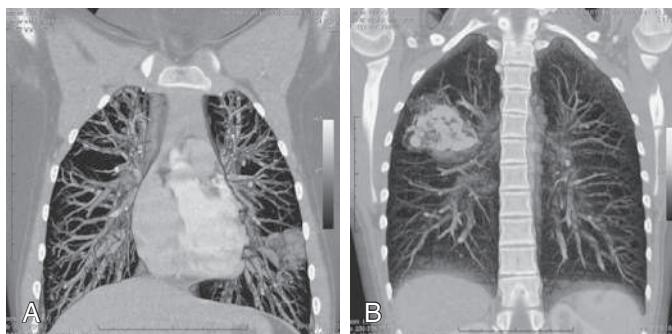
A, Volume-rendering reconstruction of the contrast-enhanced spiral CT showing a large arteriovenous fistula in the left upper lobe (lingula). B, Volume-rendering reconstruction of the contrast-enhanced spiral CT showing an arteriovenous fistula in the right upper lobe. (From Grzela K, Krenke K, Kulus M. Pulmonary arteriovenous malformations: clinical and radiological presentation. *J Pediatr*. 2011;158:856, Figs. 1 and 2.)
